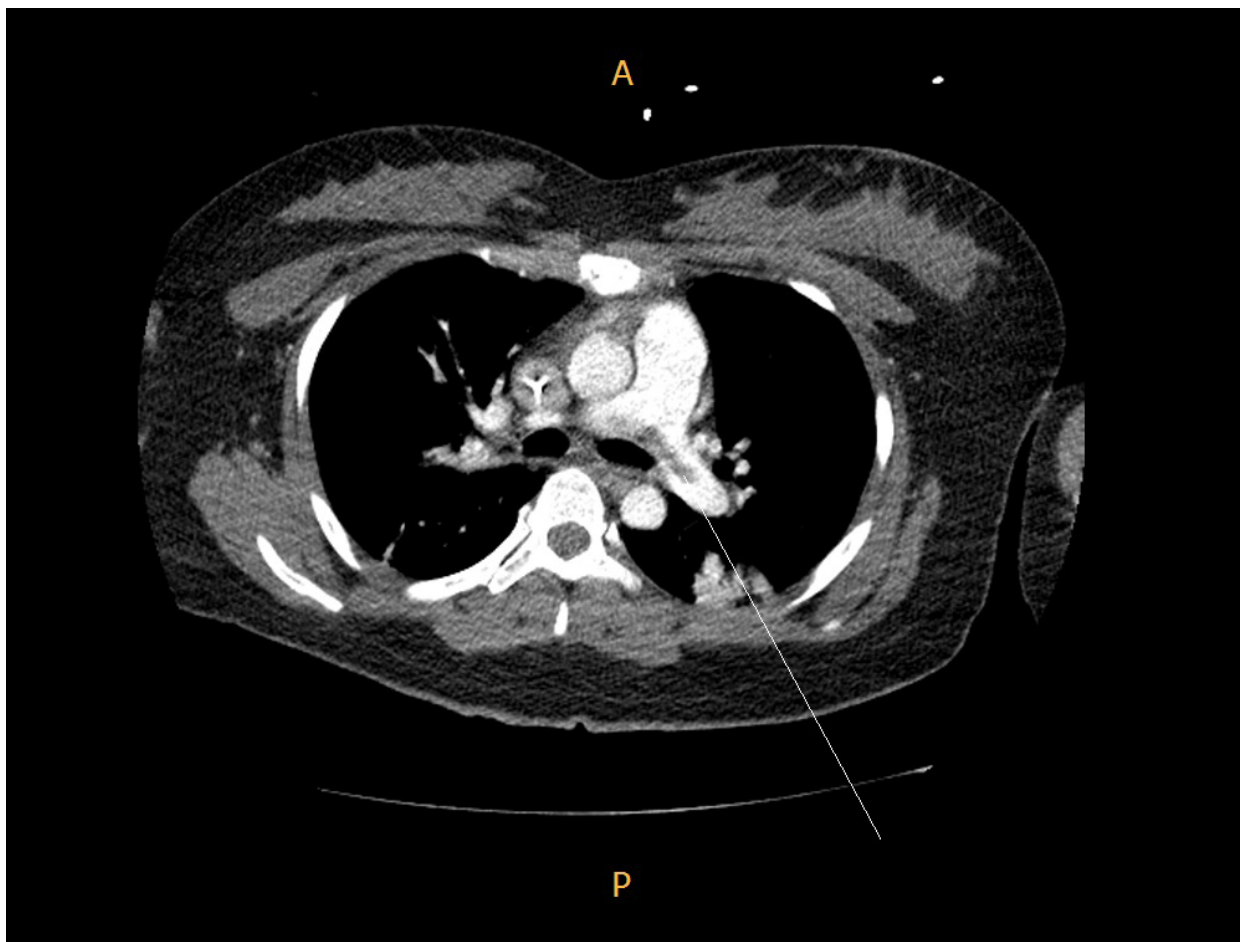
Contrast-enhanced chest CT shows pulmonary thromboembolism in both main pulmonary artery and segmental branches of BLL (↑ thrombi). (B) Chest X ray shows pulmonary edema on both lungs, bilateral moderate amount of pleural effusion and R/O pulmonary embolism.
